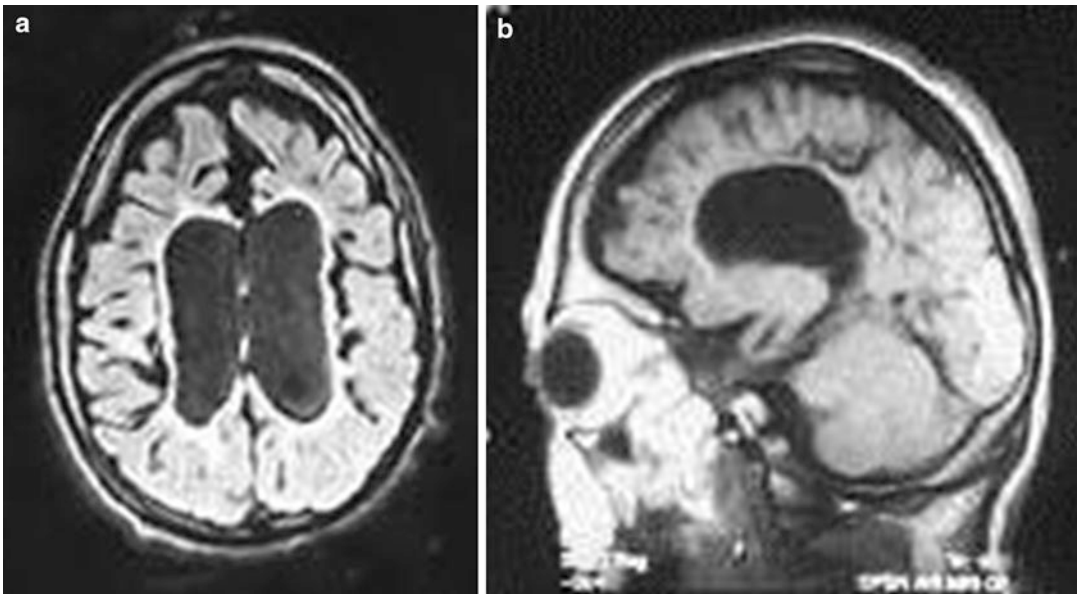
(a, b) CT scans of the brain of a patient showing dilatation of the lateral ventricles with stretching of the corpus callosum and cortical atrophy
